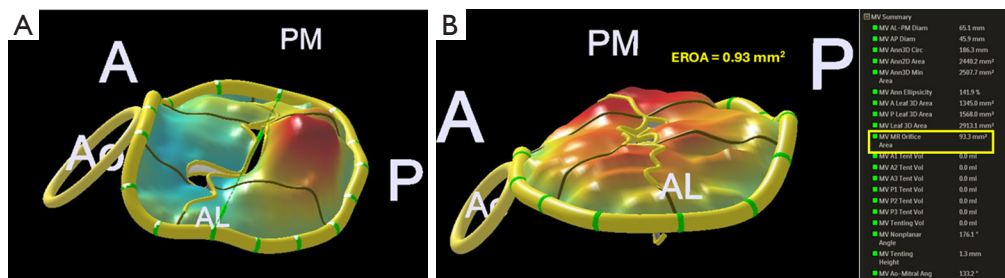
Parametric models of the mitral valve. (A) 3D TEE parametric model of the mitral valve, demonstrating a flail middle scallop (P2) of the posterior leaflet. (B) 3D TEE parametric model of the mitral valve, showing bileaflet prolapse. The red color represents leaflet tissue that is located above the annular plane during systole due to prolapse or flail. 3D, three-dimensional; A, anterior; AL, anterolateral; EROA, effective regurgitant orifice area; MV, mitral valve; P, posterior; PM, posteromedial; TEE, transesophageal echocardiography.
